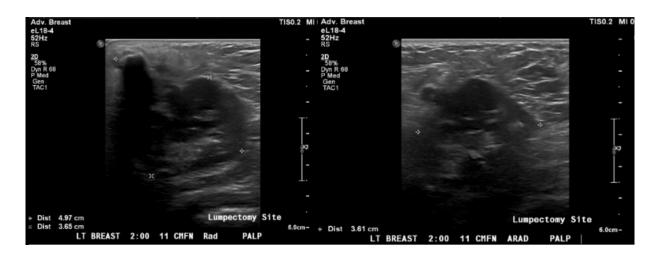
Diagnostic ultrasound of the left breast mass at the site of prior partial mastectomy. Grayscale ultrasound images in the radial (left) and antiradial (right) planes demonstrate the irregular mass with heterogeneous internal echotexture and posterior acoustic shadowing that correlate with mammography findings of the new irregular high density mass with calcifications.
